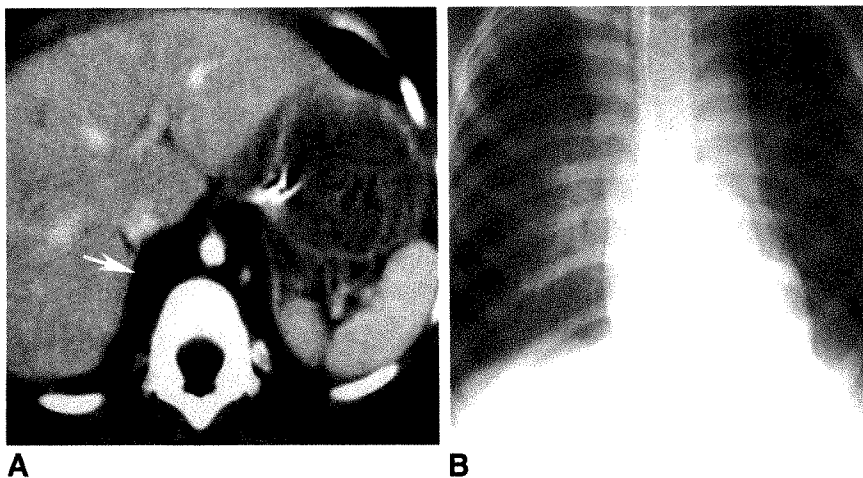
7-year-old boy struck by car. Initial chest radiograph (not shown) was overexposed and did not allow evaluation of mediastinum.
